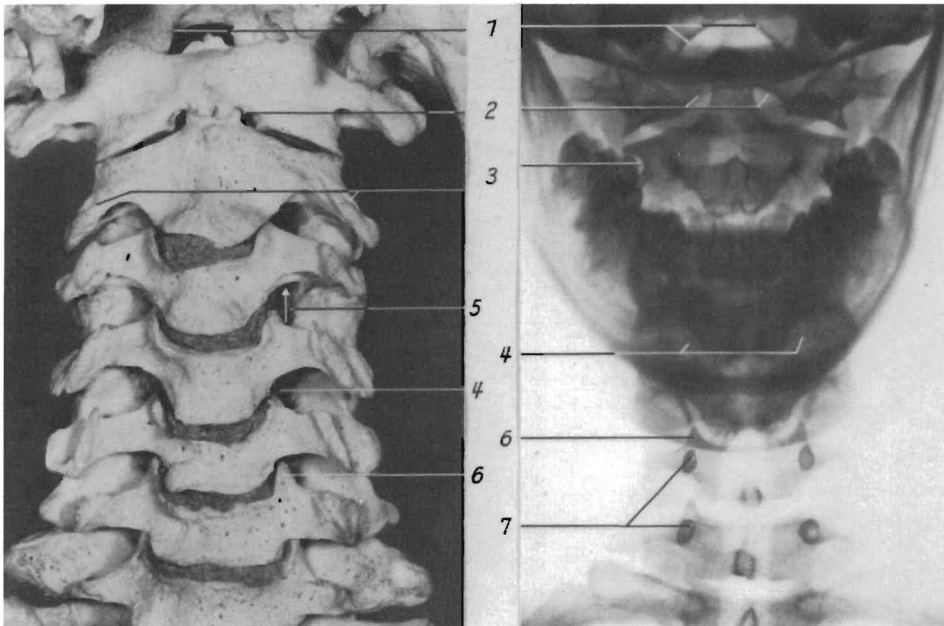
Skeleton of the cervical spine (ventral aspect) compared with the anteroposterior X-ray. 1. Anterior edge of the foramen magnum; 2, lower edge of the anterior arch of the atlas; 3, foramen costotransversarium of the axis; 4, foramen intervertebrale; 5, course of the vertebral artery; 6, unciform process; 7, pedicle
